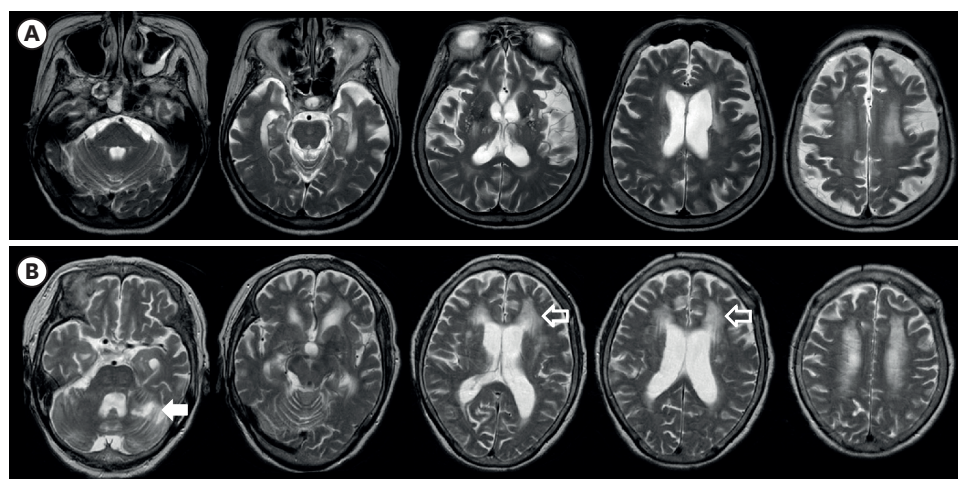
T2-weighted MRI. (A) Case 1: Image shows severe brain atrophy in the whole brain, including bilateral confluent high-signal changes in the periventricular, subcortical, and left, external capsular white matter ischemic areas. (B) MRI of case 2 showing bilateral confluent high-signal changes in the frontal periventricular, subcortical, and left cerebellar ischemic areas, indicating chronic infarction with mild ventriculomegaly (open arrow). MRI: magnetic resonance imaging.
